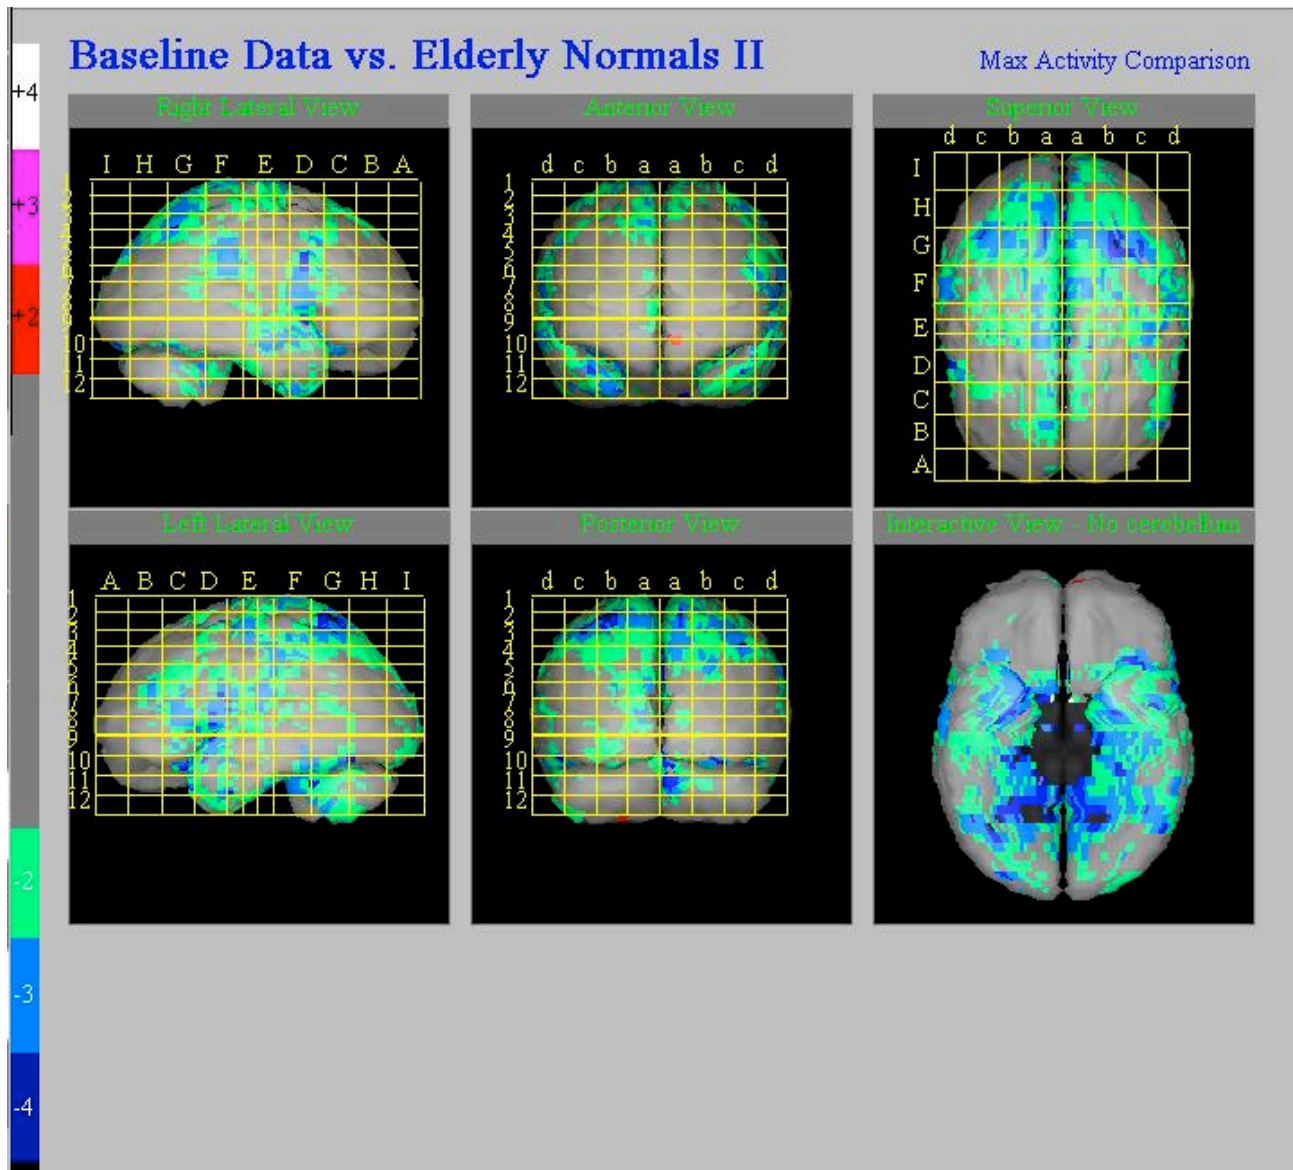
Brain ^{99m}Tc-HMPAO SPECT of a patient with AD. Volumetric reconstruction of the semiquantitative analysis. On the left part of the figure the colour bar indicating the decrease in standard deviations (SD) with respect to normal sex and age-matched control subjects is reported. A significant hypoperfusion (<2-3 SD with respect to healthy subjects of the same age and gender) is shown in the parietal, occipito-parietal and temporal regions (including Brodmann areas 37, 39 and 40 were significantly different as compared to other patients).
